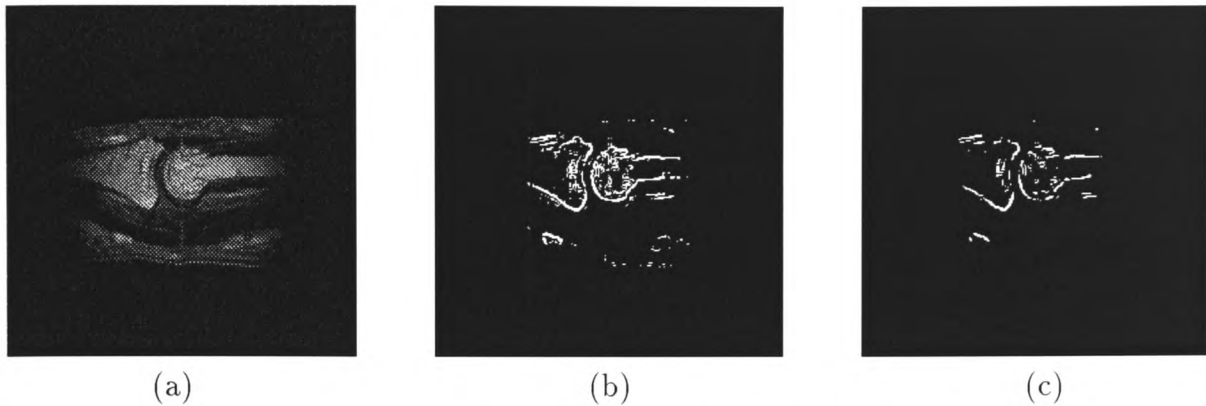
(a) MRI finger scan (b) Sobel Edge Detector (c) Prewitt Edge Detector.
